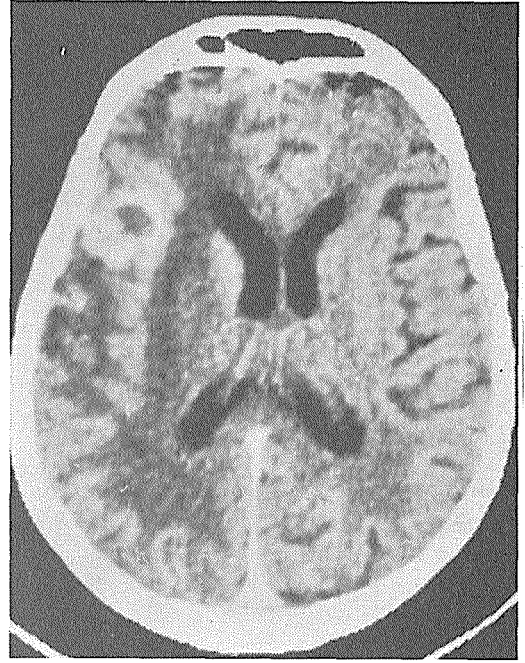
Brain CT in February 1992.
